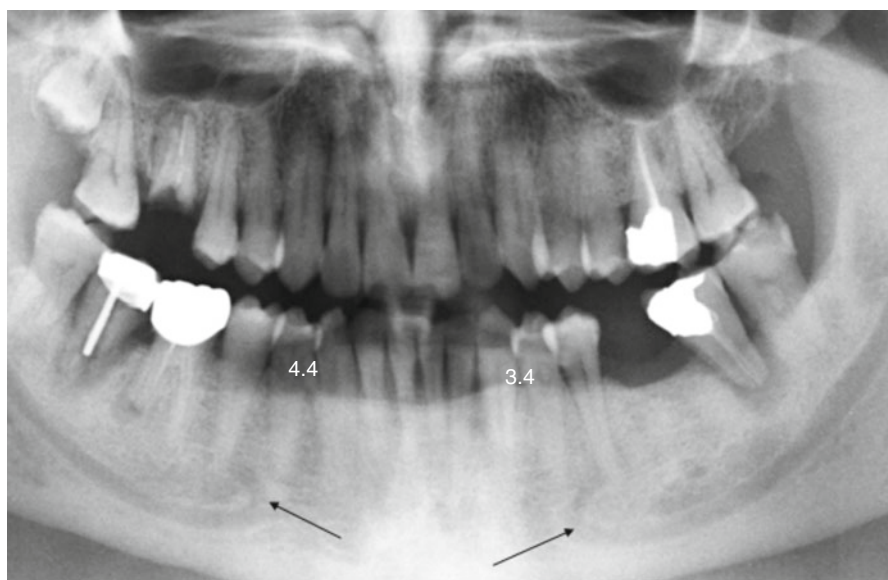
(a, b) Variability of the mental foramen seat (indicated by *arrows*). In (a) the mental foramen is at a certain distance from the apex of the second inferior right premolar (4.5). In (b) the foramen is adjacent to the second inferior left premolar (3.5) and it must not be interpreted as a periapical area of bone resorption
